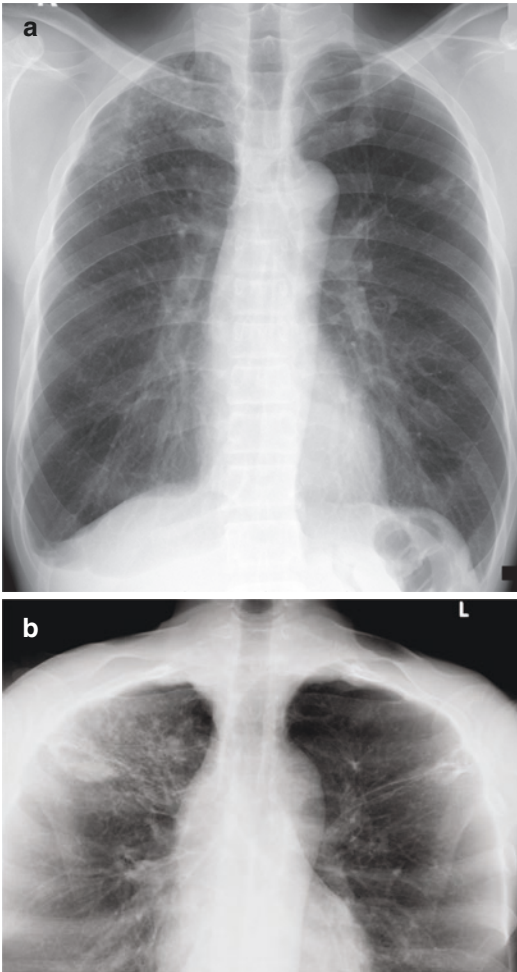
Pulmonary tuberculosis. (a) PA chest radiograph shows patchy opacities mainly in the right upper zone. Fibronodular scarring is also present in the periphery of the left mid zone. (b) Apical view radiograph in the same patient. In this projection, the opacities in the right upper lobe, as well as the left-sided scarring, are much better demonstrated, without the overlying clavicle and ribs
